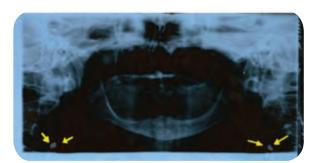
A portion of a standard panoramic radiograph that was scanned and digitized to enhance the reader's visualization of an atherosclerotic lesion in the neck (arrows). The patient had type 1 diabetes mellitus and was being treated with insulin.
